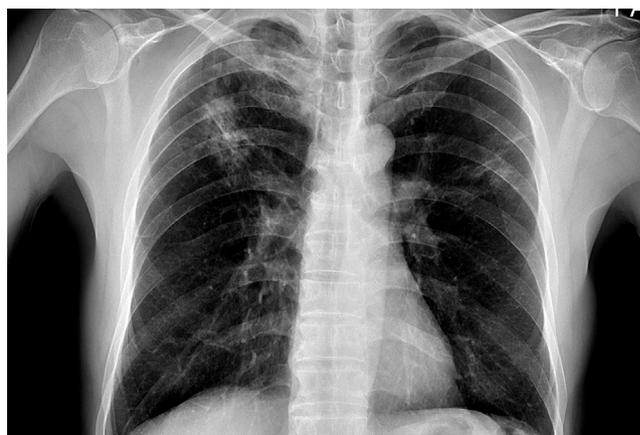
Chest radiograph demonstrates multiple nodules at both upper lobes and focal cavitary consolidation at right upper lobe, compatible with active pulmonary tuberculosis.
